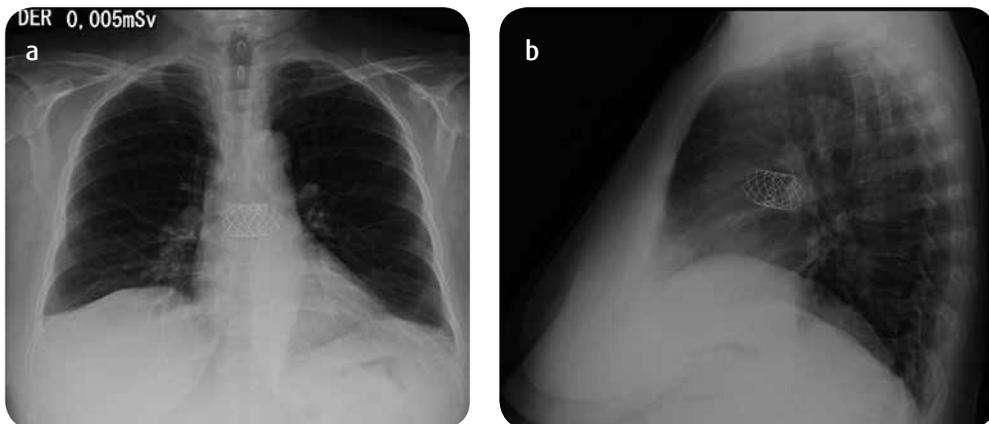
Chest radiography. a) Radiopaque element that projects in cardiac area, and corresponds to endoprosthesis. b) Endoprosthesis at the level of the main pulmonary vessels. It is not possible to estimate the exact location of the stent on the radiograph.
